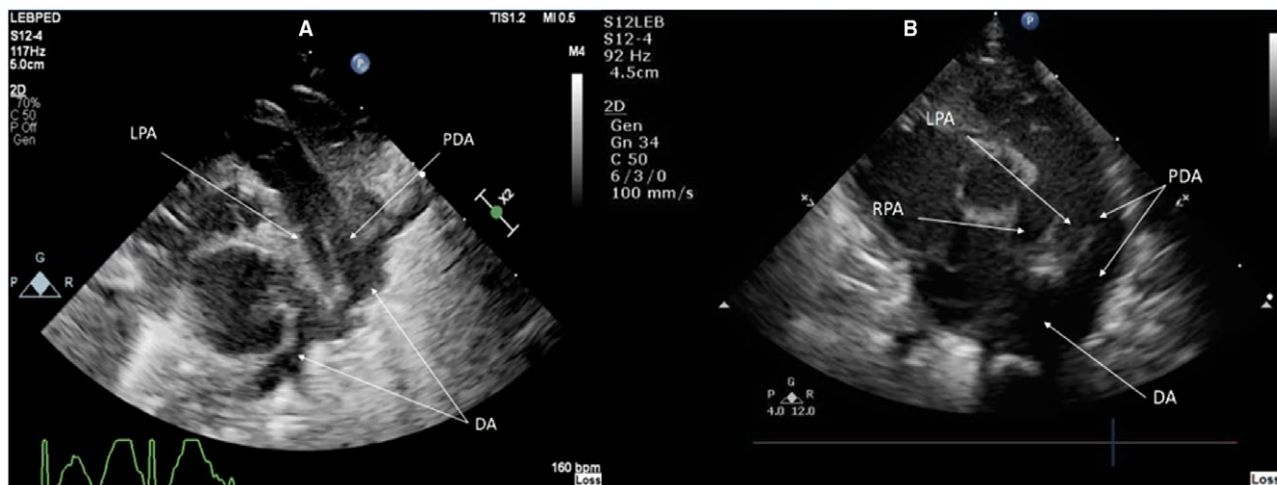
Echocardiographic images of the PDA. A, PDA in high parasternal view showing its superiorinferior extent, optimal for measuring its length and also the diameters (notice that the DA is displayed longitudinally which suggests that the imaging plane is closer to parasagittal plane rather than transverse). B, PDA in parasternal short-axis view showing its anteroposterior extent, the diameters can be measured but it is not optimal for measuring its length (notice that DA is displayed axially suggesting that the imaging plane is closer to transverse body plane). Abbreviations: DA, descending aorta; LPA, left pulmonary artery; PDA, patent ductus arteriosus; RPA, right pulmonary artery
